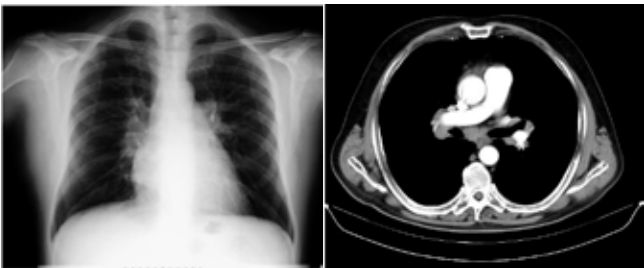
PA chest radiography demonstrating bilateral hilar enlargement and thoracic CT images demonstrating bilateral hilar and subcarinal lymphadenopathy (a,b)
